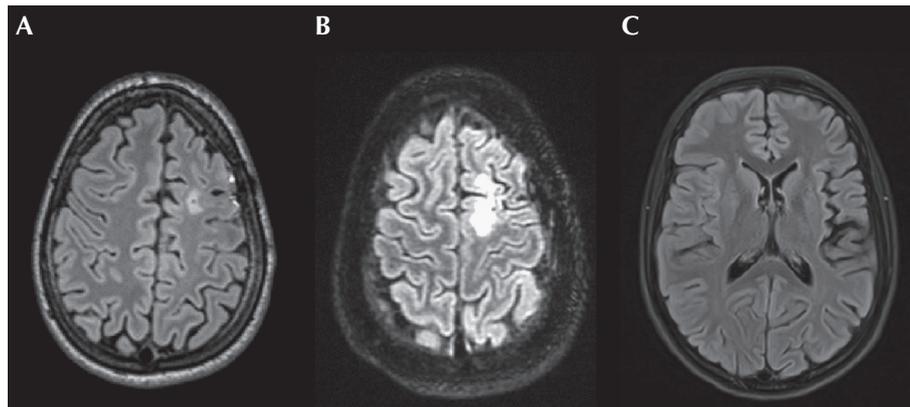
(A) Initial MRI showing hyperintense FLAIR lesions of the left frontal superior gyrus. (B) Second MRI showing progression of the lesions. (C) MRI showing left sylvian valley atrophy.
